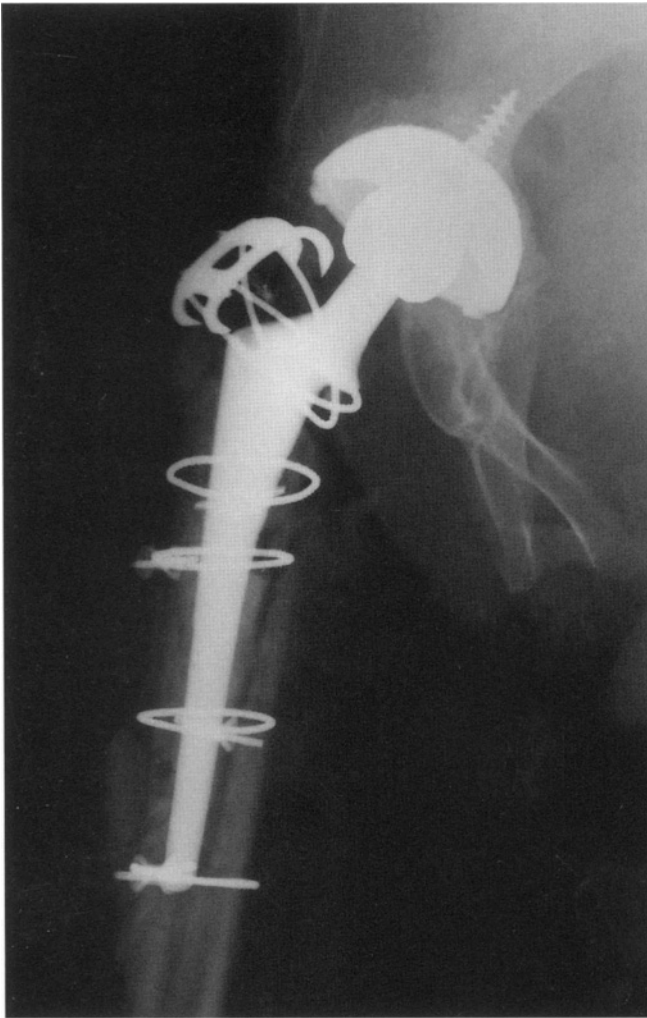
Plain radiograph of infected total hip arthroplasty. A proximal femur resection was performed, and the bone defect was reconstructed with a temporary spacer, composed of proximal femur prosthesis wrapped with cement and antibiotics. Following a prolonged course of intravenous antibiotics the spacer was replaced by a fixed cemented proximal femur prosthesis.
